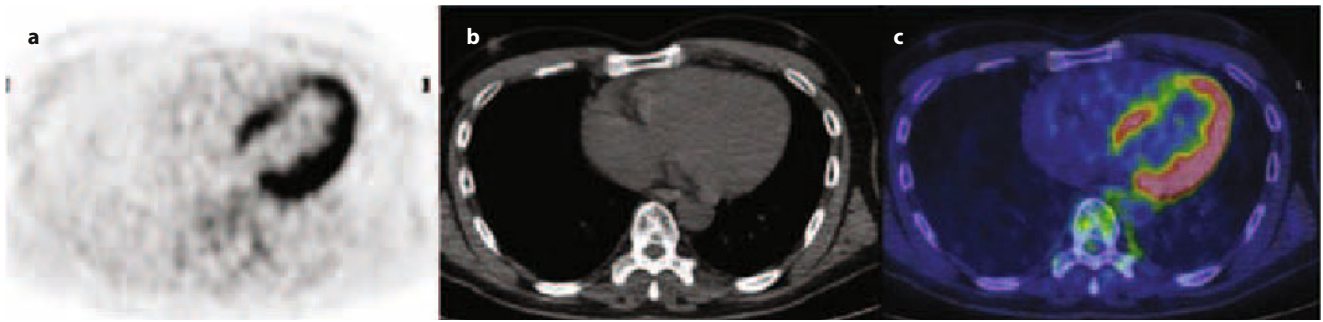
Transaxial [^{18}F]FDG-PET/CT images (PET in a, CT in b, fused PET/CT in c), showing intense myocardial [^{18}F]FDG uptake with an area of reduced uptake in the septum in a patient with left bundle-branch block
